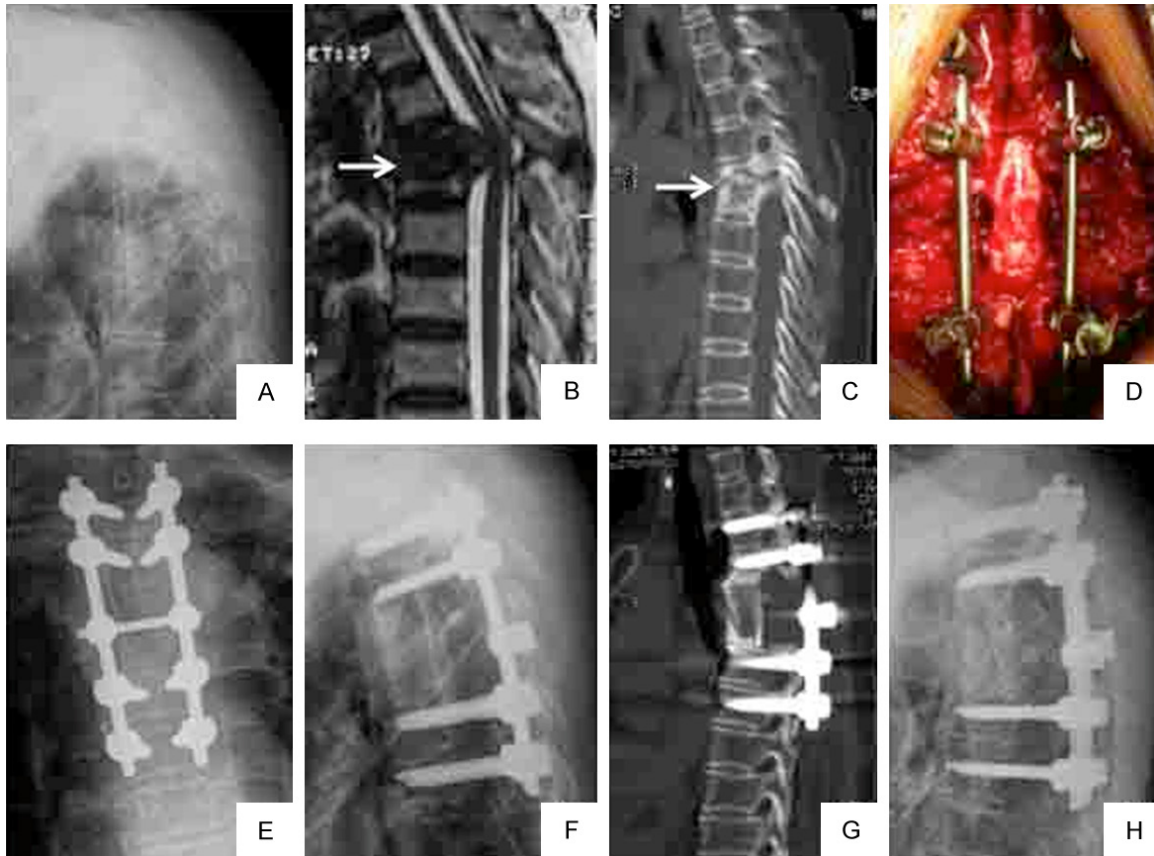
A 45-year-old female with T4 tuberculosis underwent posterior debridement, iliac bone autograft, and medical screw fixation. A: Lateral plain radiograph demonstrated a tuberculous focus at T4 and a kyphotic angle of 42.6°; B, C: Magnetic resonance imaging (MRI) and computed tomography (CT) scan demonstrate vertebral destruction and paravertebral and epidural abscess with compression of the spinal cord (white arrow); D: Intraoperative photograph demonstrates the TB focus was thoroughly debrided via a posterior-only approach. E: Postoperative AP X-ray show that one-stage posterior debridement graft fusion and pedicle screw fixation was performed; F: Lateral plain radiograph show that the postoperative kyphotic angle restored to 18.2°; G: CT scan of the sagittal plane demonstrated solid fusion at 8-month follow-up; H: Postoperative plain lateral radiograph of final follow-up shows that there is no fixation failure and obvious correction loss.
